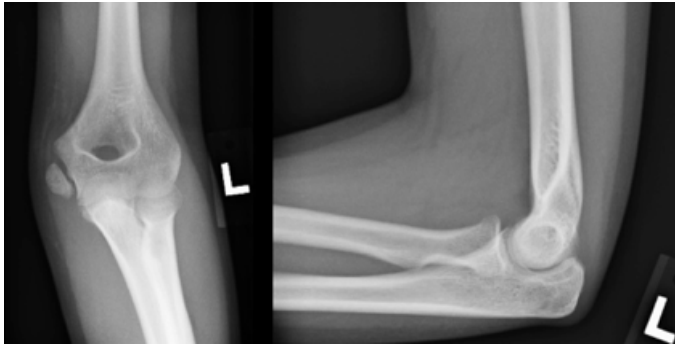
Initial injury x-rays.
